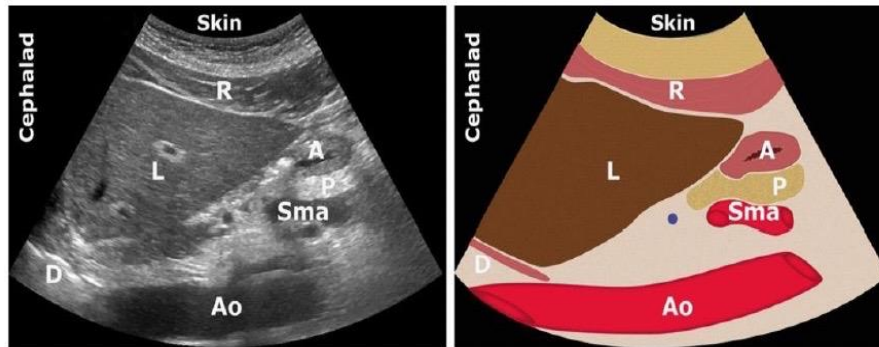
Ultrasound image showing empty antrum. A – Antrum, P – Pancreas, Sma – Superior mesenteric artery, Ao – Aorta, D – Duodenum, L – Liver, R – Rectus abdominis muscle
